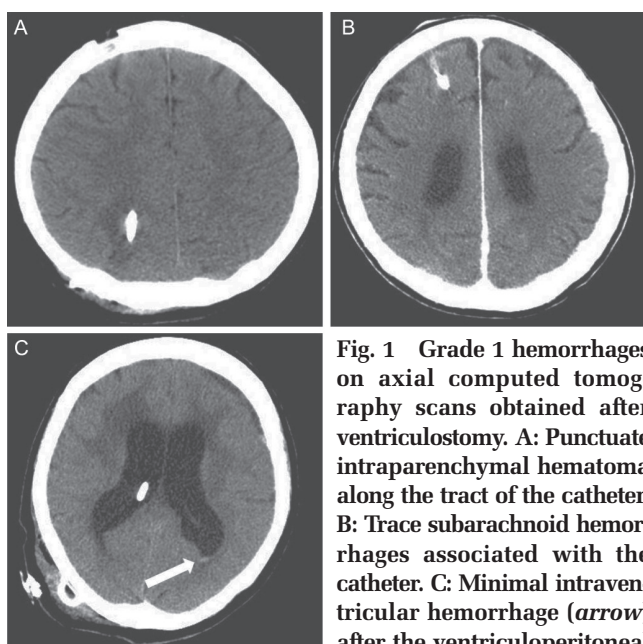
Grade 1 hemorrhages on axial computed tomography scans obtained after ventriculostomy. A: Punctate intraparenchymal hematoma along the tract of the catheter. B: Trace subarachnoid hemorrhages associated with the catheter. C: Minimal intraventricular hemorrhage (*arrow*) after the ventriculoperitoneal shunt procedure.
